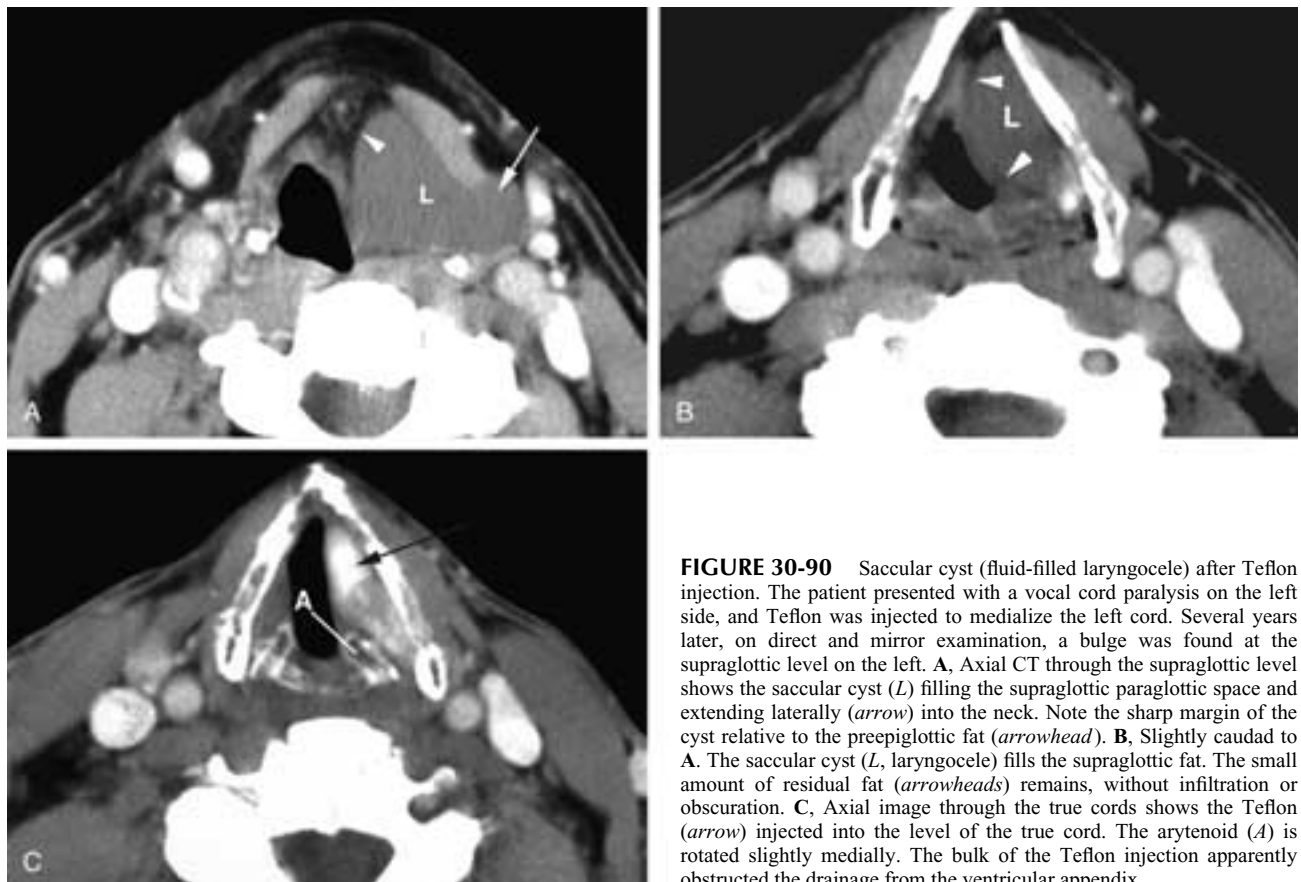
Saccular cyst (fluid-filled laryngocoele) after Teflon injection. The patient presented with a vocal cord paralysis on the left side, and Teflon was injected to medialize the left cord. Several years later, on direct and mirror examination, a bulge was found at the supraglottic level on the left. A, Axial CT through the supraglottic level shows the saccular cyst (L) filling the supraglottic paraglottic space and extending laterally (arrow) into the neck. Note the sharp margin of the cyst relative to the preepiglottic fat (arrowhead). B, Slightly caudal to A. The saccular cyst (L, laryngocoele) fills the supraglottic fat. The small amount of residual fat (arrowheads) remains, without infiltration or obscuration. C, Axial image through the true cords shows the Teflon (arrow) injected into the level of the true cord. The arytenoid (A) is rotated slightly medially. The bulk of the Teflon injection apparently obstructed the drainage from the ventricular appendix.
